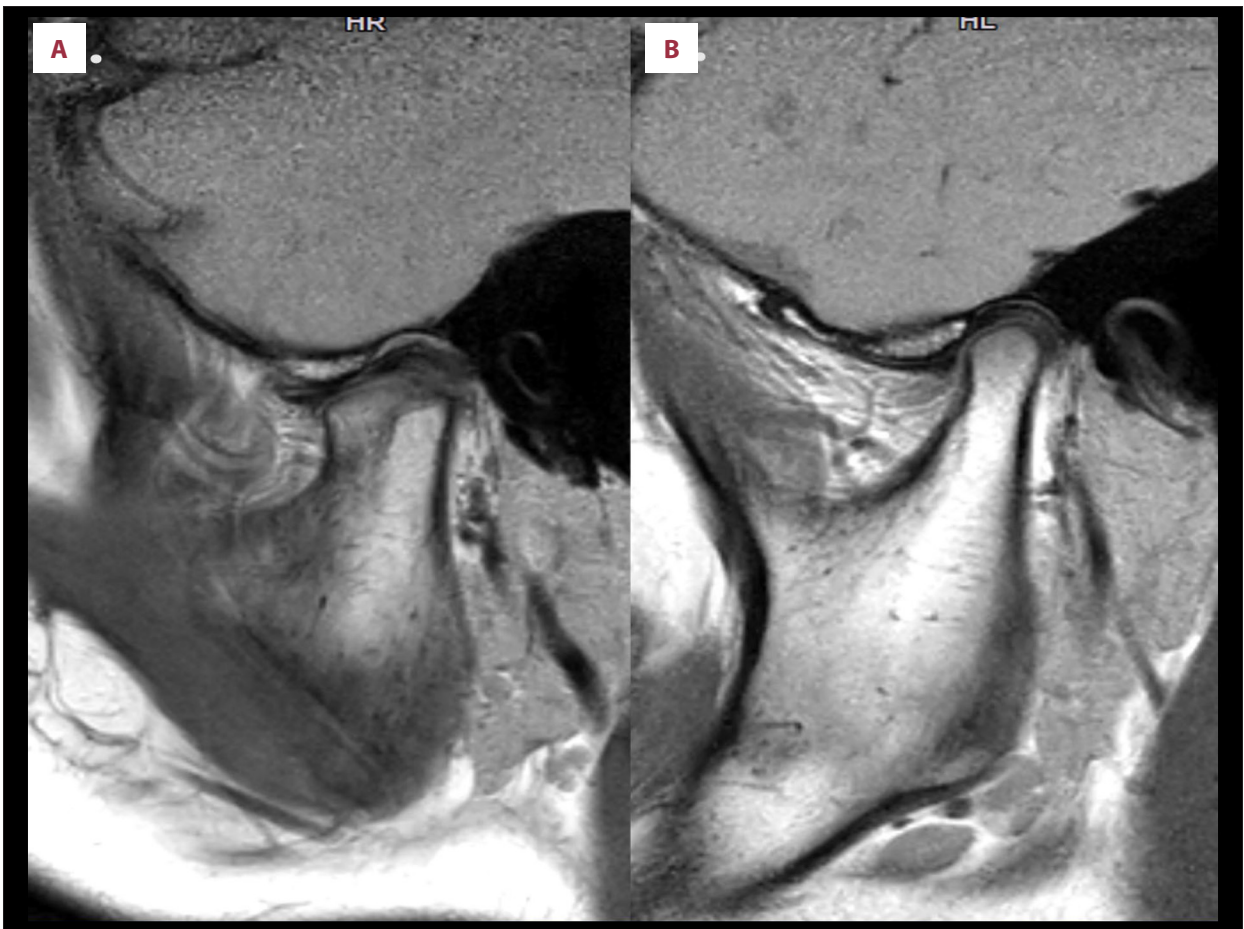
Magnetic resonance imaging (MRI): (A) right high-neck condylar fracture, and (B) normal left condyle.
